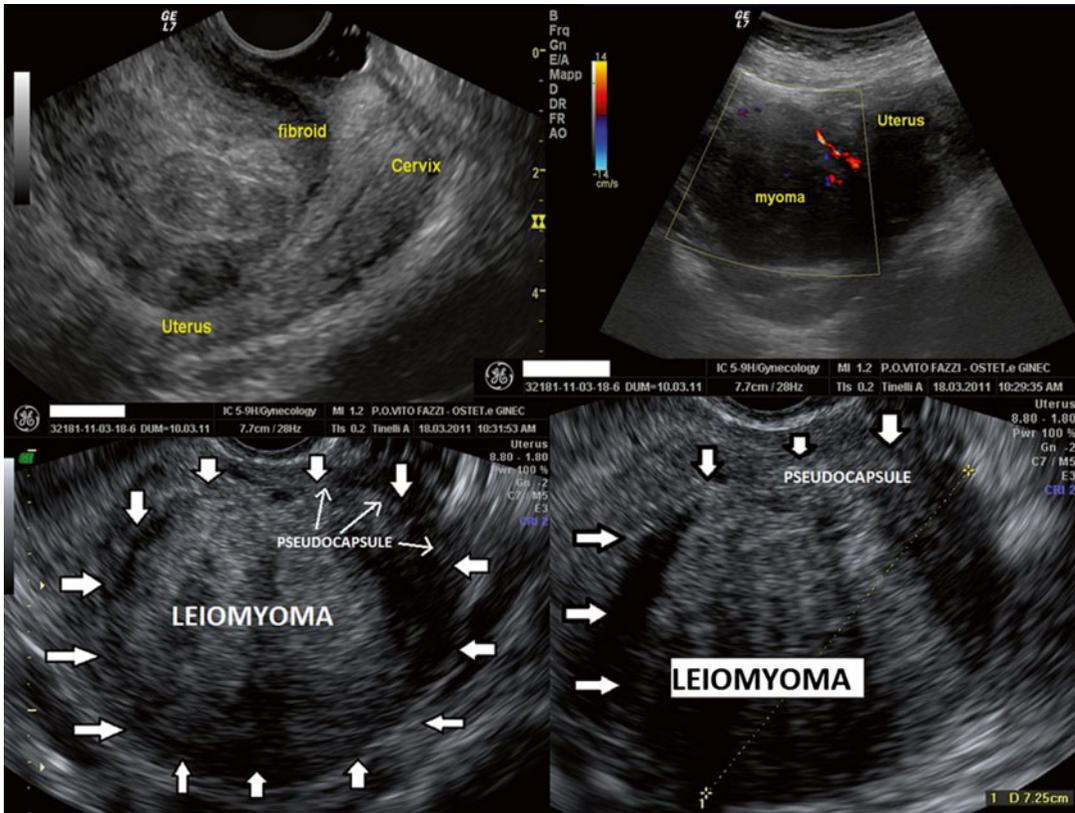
The ultrasonographic figure shows isthmic–cervical pseudocapsules, rich of ENK-positive and OXT-positive nerve fibers
